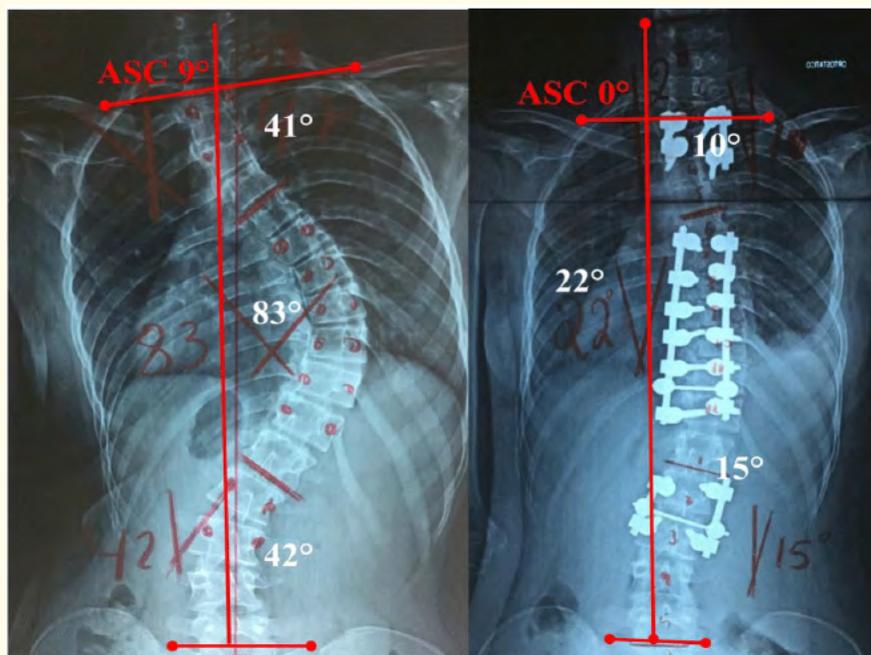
A 14-year-old female patient with an AIS. On the preoperative radiograph the left was ASC of 9°. Image to the right of the postoperative period, submitted to the fixations, apical, short and multiple, measured ASC of 0°.
